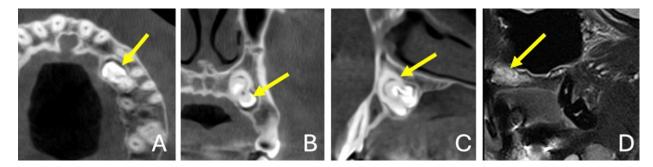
(A. B. C.) Axial, coronal, and sagittal CBCT sections of an odontoma, highlighting its mixed radiographic appearance and well-defined peripheral borders. (D) Sagittal section of a Spin Echo Magnetic Resonance Image of the odontoma, displaying both hyperintense and hypointense structures. Arrows denote the complex odontoma
